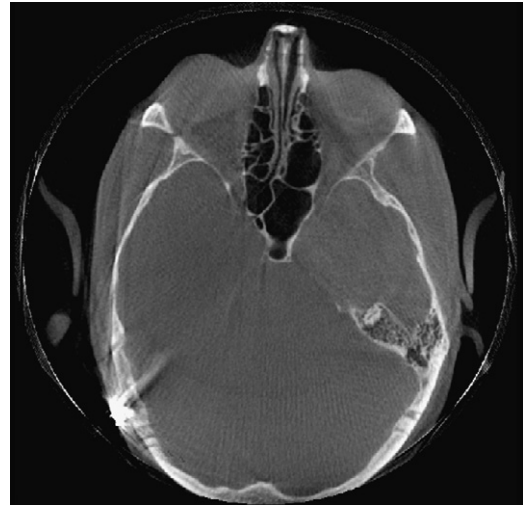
Streak artifact from bone-anchored device in CBCT.
